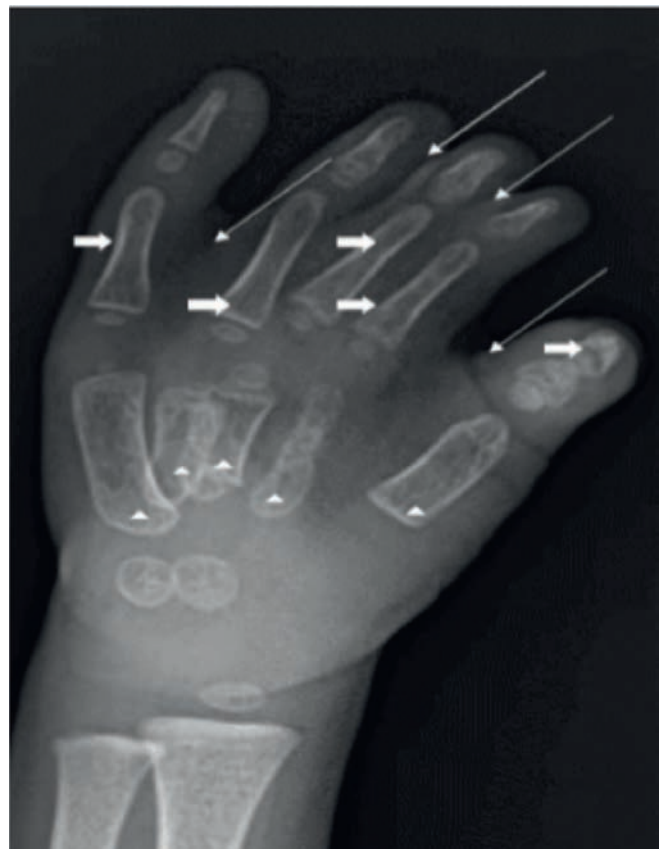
Radiograph anteroposterior view (AP) of the left-hand shows short and tubular metacarpals as indicated by a white arrowhead with the appearance of all corresponding primary ossification centers at physal ends without evidence of fusion; short fingers with absent middle phalanx as indicated by the white thick short arrow. Suspicion of soft tissue syndactyly between the first and second digit (thumb and index finger), and between the second, third, and fourth digits (index, middle, and ring fingers) with relatively separate/longer fifth digit (little finger) as indicated by the white long arrow. No evidence of osseous syndactyly of the left hand
